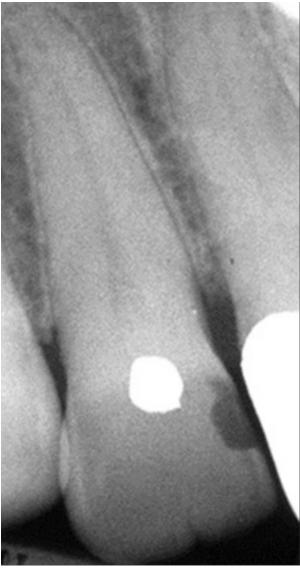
Periapical radiograph of maxillary lateral incisor tooth #7 with coronal cleft.
